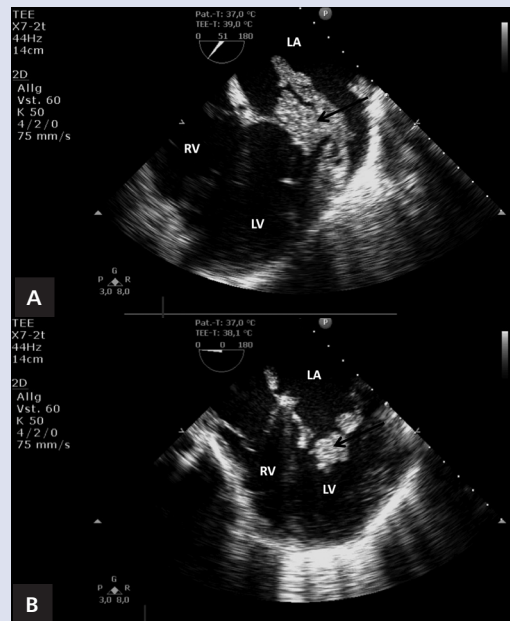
Two-dimensional transoesophageal echocardiographic examination, modified (51°) midesophageal four-chamber view. The ramified, hyperechoic structure on the mitral valve is to be seen; A. Systole; B. Diastole; LA — left atrium; LV — left ventricle; RV — right ventricle; black arrow depicts the hyperechoic structures on the mitral valve
